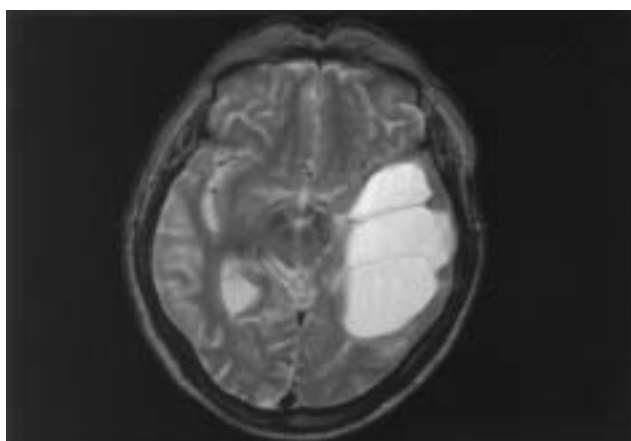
Axial view of brain T2-weighted MRI showed a huge cystic lesion with septum.
